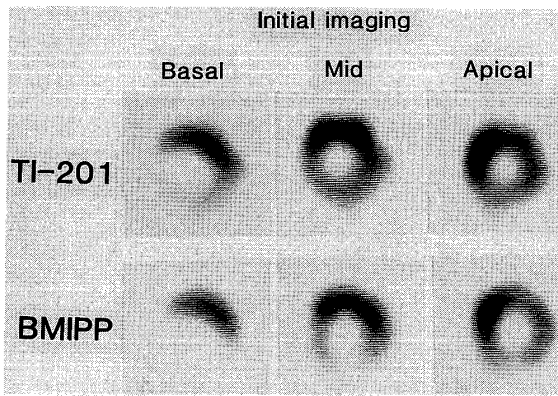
Initial resting dual SPECT imaging with  $^{201}\text{Tl}$  (upper panel) and  $^{123}\text{I}$ -BMIPP (lower panel) in patient 5. SPECT images show short-axis slices in basal, mid, and apical portions. The uptake of  $^{123}\text{I}$ -BMIPP is less than that of  $^{201}\text{Tl}$  in the inferior region.
